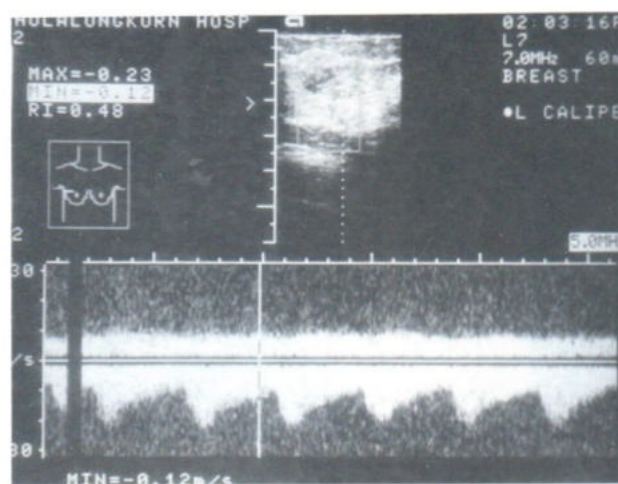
Color Doppler study shows increased vascularity in the mass.
